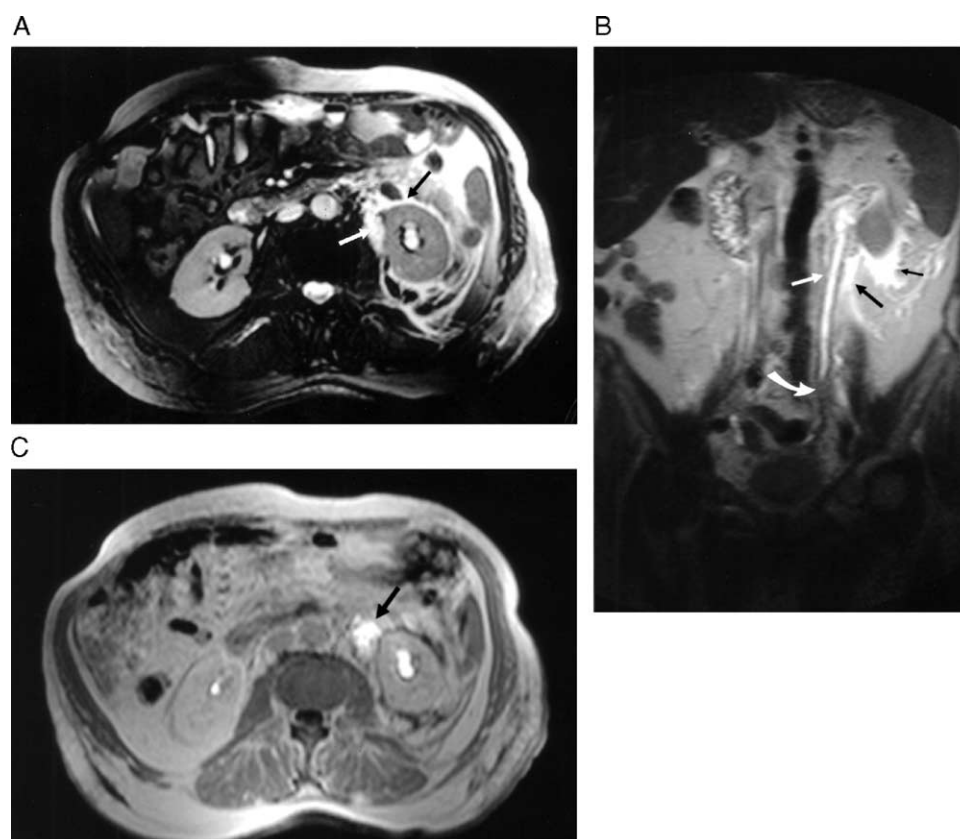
MRI of a 32-year-old patient who presented with retroperitoneal fibrosis with complicated hydronephrosis on follow-up. (A) Axial T2-weighted balanced fast field echo image (TR/TE/FA, 4.8/2.1/70) showing hyperintense perinephric fluid collection (arrows). (B and C) Coronal T2-weighted half-Fourier single-shot fast spin echo images showing dilated ureter (white straight arrow, B) and the causing retroperitoneal fibrosis (curved arrow, B). The retroperitoneal perinephric fluid collection is also visible (black straight arrows, B). (C) Late contrast-enhanced T1-weighted SGE image (TR/TE/FA, 150/4.2/80) showing retroperitoneal contrast extravasation (arrow).
